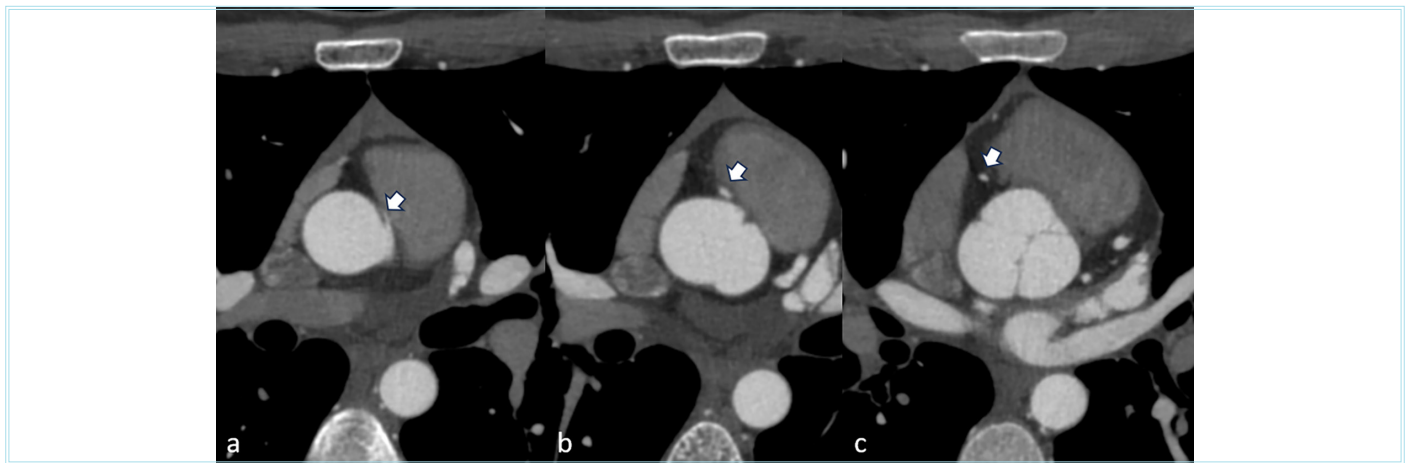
This is a case showing an anomalous RCA originating from the left main coronary artery and having an interarterial course. (a, b, c) Axial CT angiography images show that the RCA originates from the left main coronary artery, (white arrows) coursing between the great vessels
